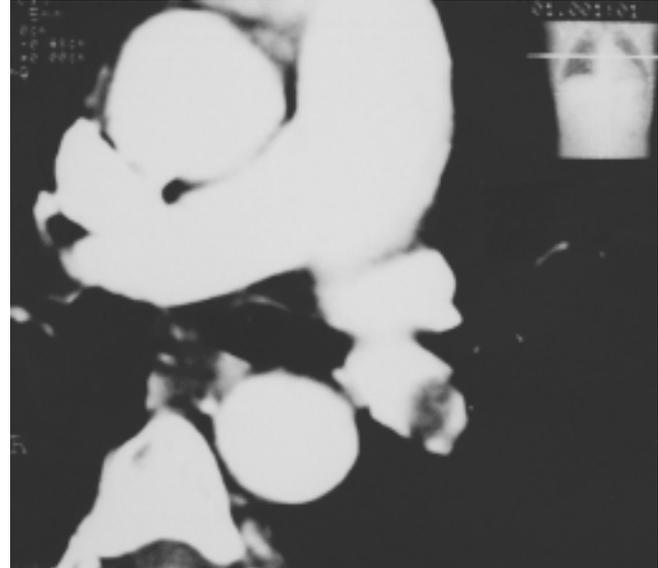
"CTA showing filling defect in left descending pulmonary artery.
